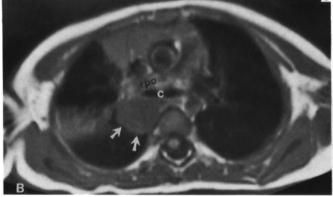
(A) Frontal radiograph of a three-year-old female with persistent cough demonstrates a subcarinal mass (*arrows*). (B) Cross-sectional MRI image demonstrates the relation of the lesion (*arrows*) to the right pulmonary artery (*rpa*) and carina (*c*). Thoracoscopy through the right chest revealed a bronchogenic cyst that was completely excised without thoracotomy. (By permission of G. Holcomb (ed.), *Pediatric Endoscopic Surgery*, Appleton & Lange, Norwalk, CT, 1993, p. 207.)
